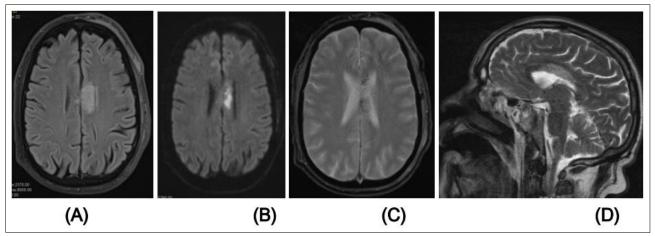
A-D: (A): Axial section FLAIR, (B): Diffusion restriction, (C): T2*, (D): Sagittal section T2: Acute infarction of the body of the corpus callosum extending to the splenium with hemorrhagic foci on T2*
